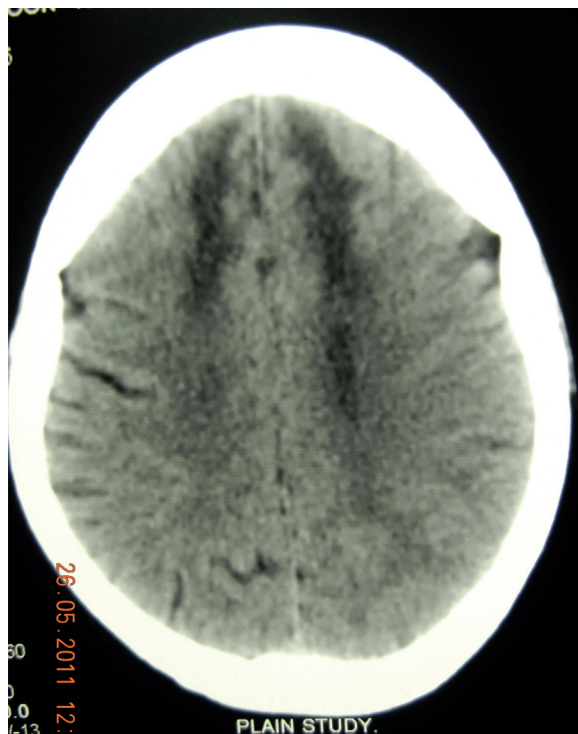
Non-contrast CT scan of brain.
